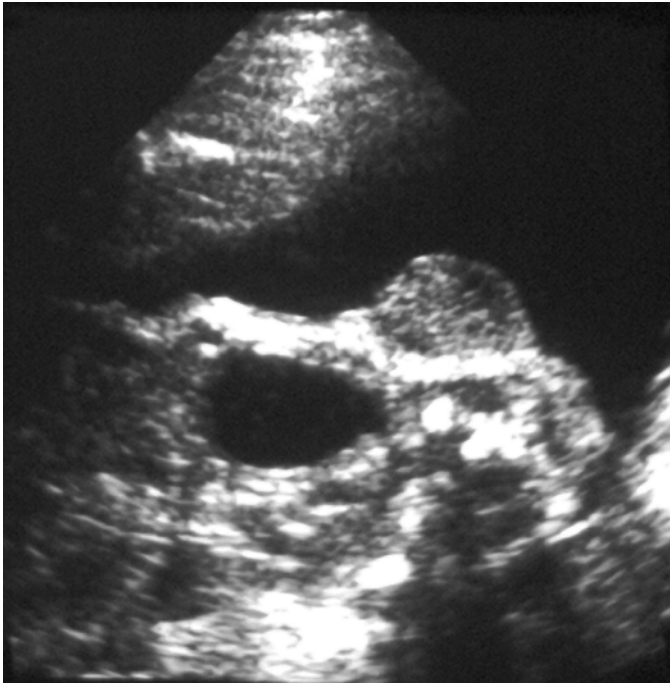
Prenatal ultrasonographic appearance of the bladder posterior urethral valve. The bladder is large and its wall is thick. The proximal urethra appears enlarged.
